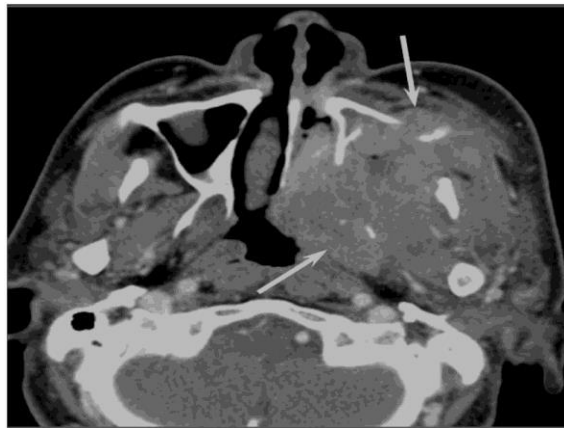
Squamous cell carcinoma of the Lt maxillary sinus. Contrast-enhanced axial CT image showing an ill-demarcated, heterogeneously enhanced bulky mass with extensive bony destruction (arrows)(
